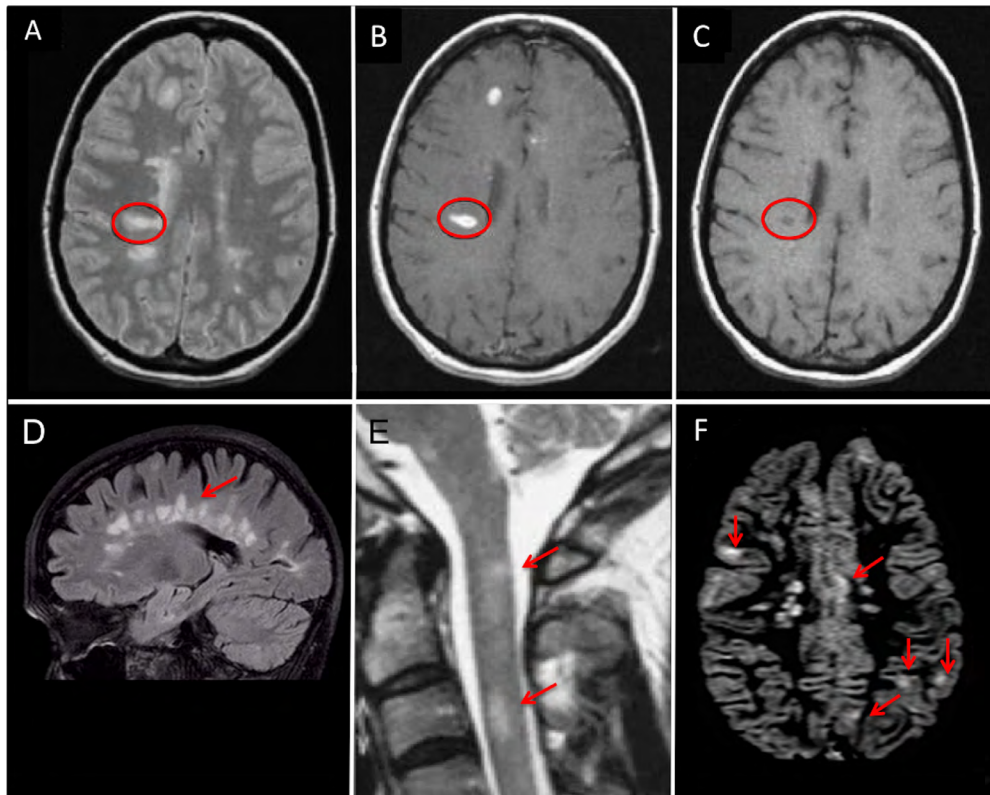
Conventional MRI in MS.
